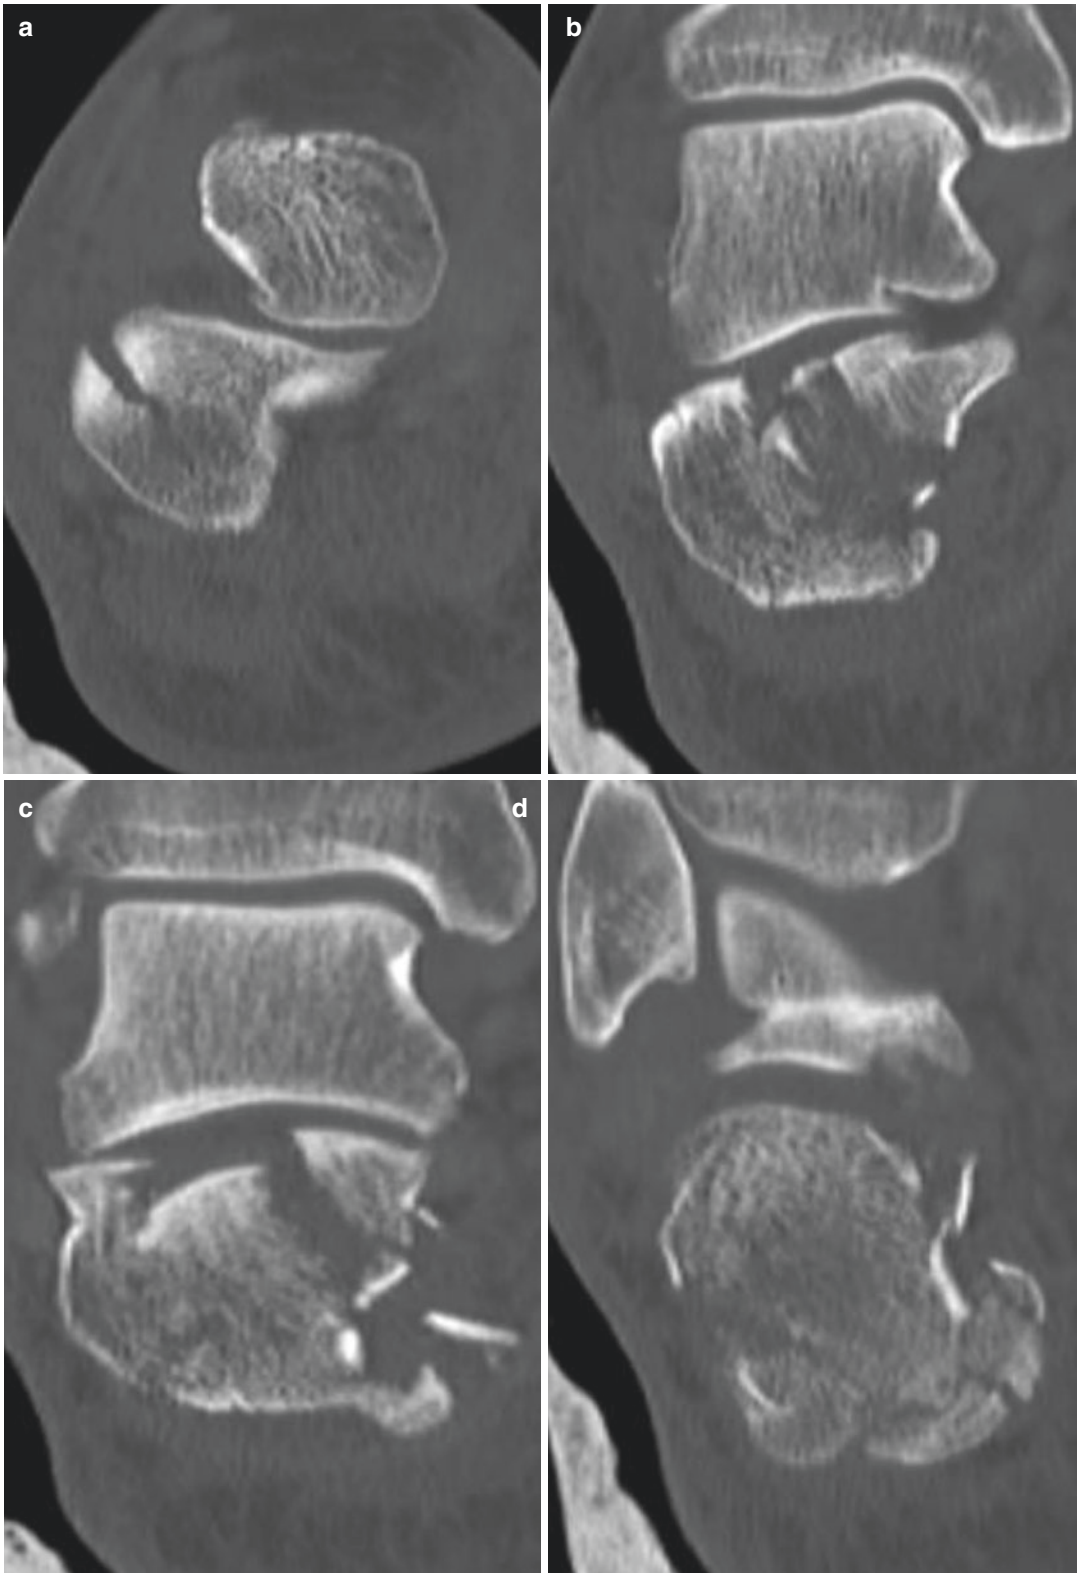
Coronal CT images
